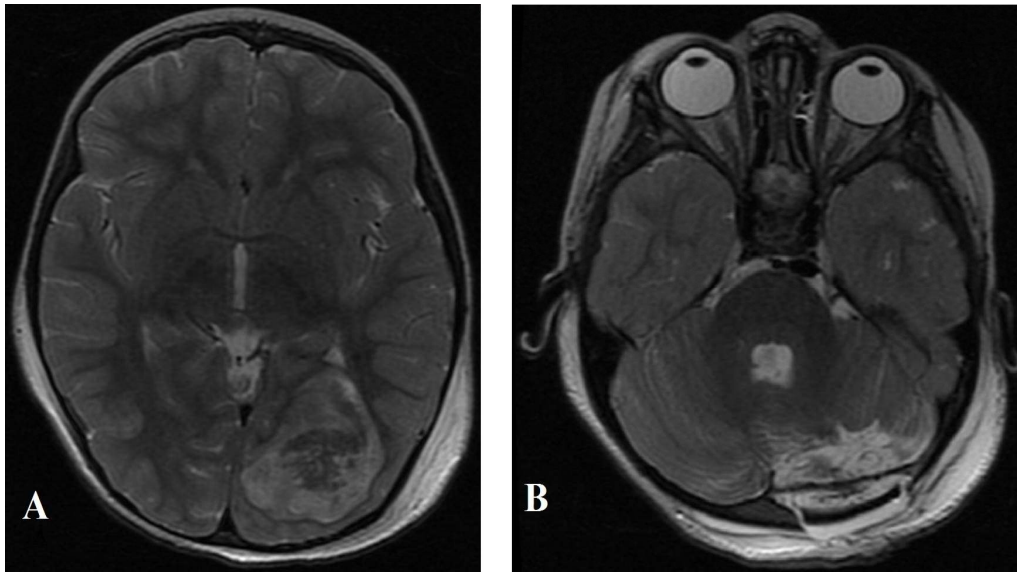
T2 weighted MRI shows the tumor recurrency in the left occipital lobe (A) and in the postoperative cystic lesion in the left cerebellum and in the tentorium (B).
